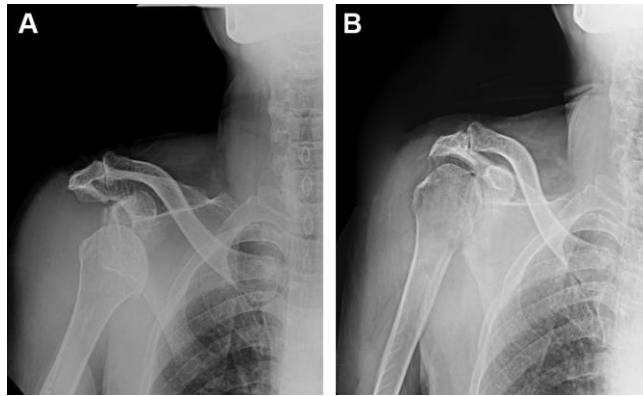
(A) A radiograph of a 68-year-old man with a first dislocation of the right shoulder. (B) After reduction, plain radiography revealed rotator cuff arthropathy with osteophytes under the acromion and superior migration of the humeral head.
